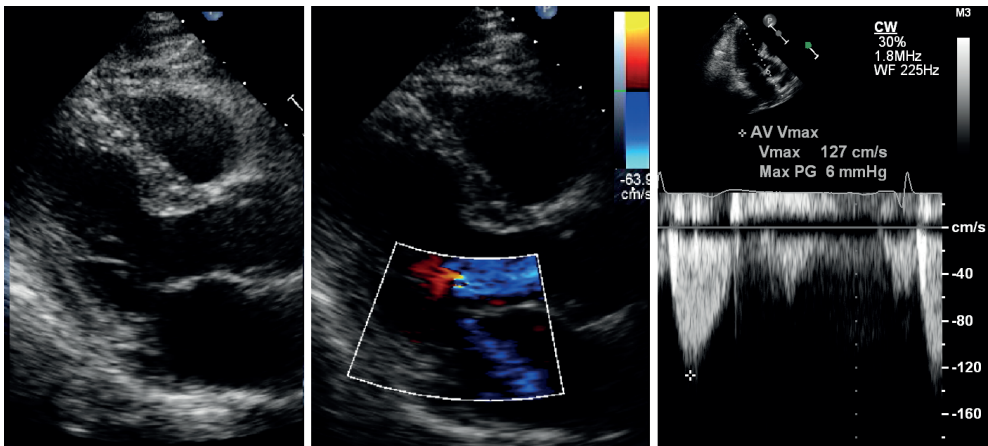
Post-operative 2D and doppler echocardiography, in which no SAM or mitral regurgitation is present. Left ventricular outflow tract gradient is not increased.
